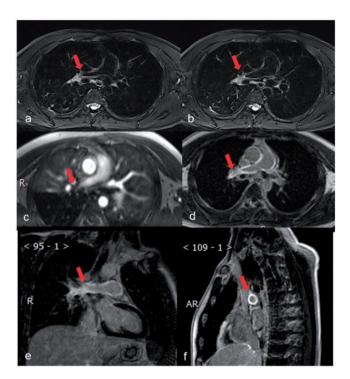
MRI of a 33-year-old female patient with TA. (a and b) axial fatsuppressed T2WI shows right pulmonary artery stenosis with concentric mural thickening (red arrow); (c) axial contrast-enhanced MRA showed right pulmonary artery stenosis and lower lobe pulmonary artery occlusion (red arrow); (d) axial delayed contrast-enhanced MRI showed delay enhancement in right pulmonary arterial wall (red arrow); (e) delayed contrast-enhanced MRI in oblique coronal plane shows contrasted-enhancement in right pulmonary arterial wall (red arrow); and (f) delayed contrast-enhanced MRI in oblique sagittal plane shows concentric enhancement in right pulmonary arterial wall (red arrow).
